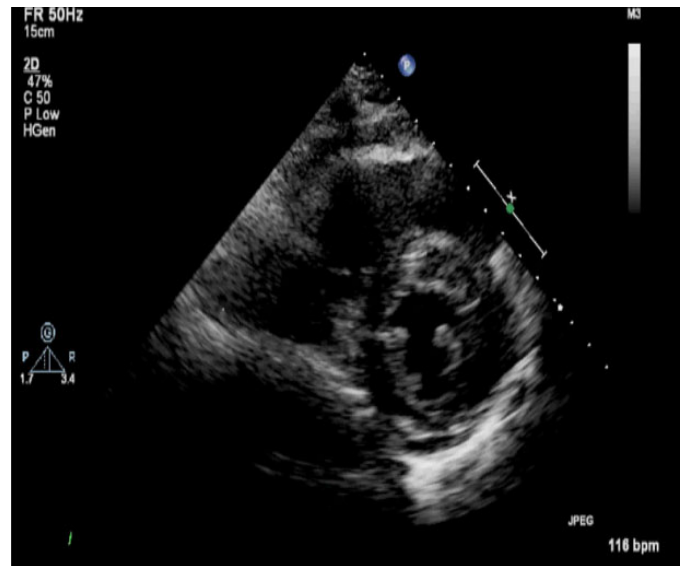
Normalization of biventricular systolic function (Parasternal short axis view).
